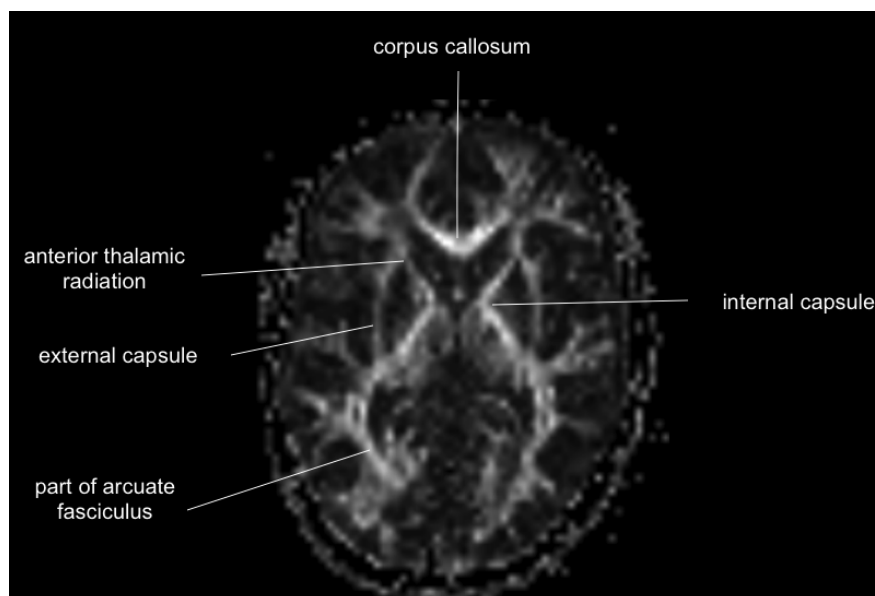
White matter anatomy. Axial fractional anisotropy (FA) MRI slice highlighting white matter tracts. This FA map shows white matter tracts with high FA as hyperintense.
